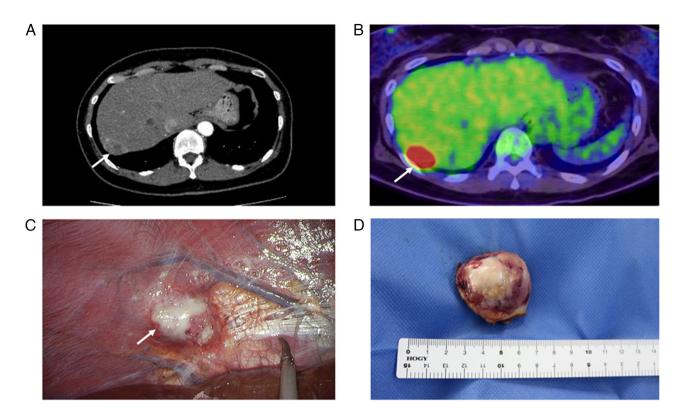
Imaging findings. (A) Enhanced CT showed an enhanced round mass at the limbus of the right hepatic lobe (arrow). (B) PET/CT showed accumulation of FDG at the site corresponding to the mass in (A) (arrow). Malignant tumor of hepatic or peritoneal origin was considered in the differential diagnosis. (C) Laparoscopic examination revealed a tumor on the right diaphragm (arrow). (D) Macroscopic examination revealed a solid and flat tumor of 4.1x3.8 cm. CT, computed tomography.
